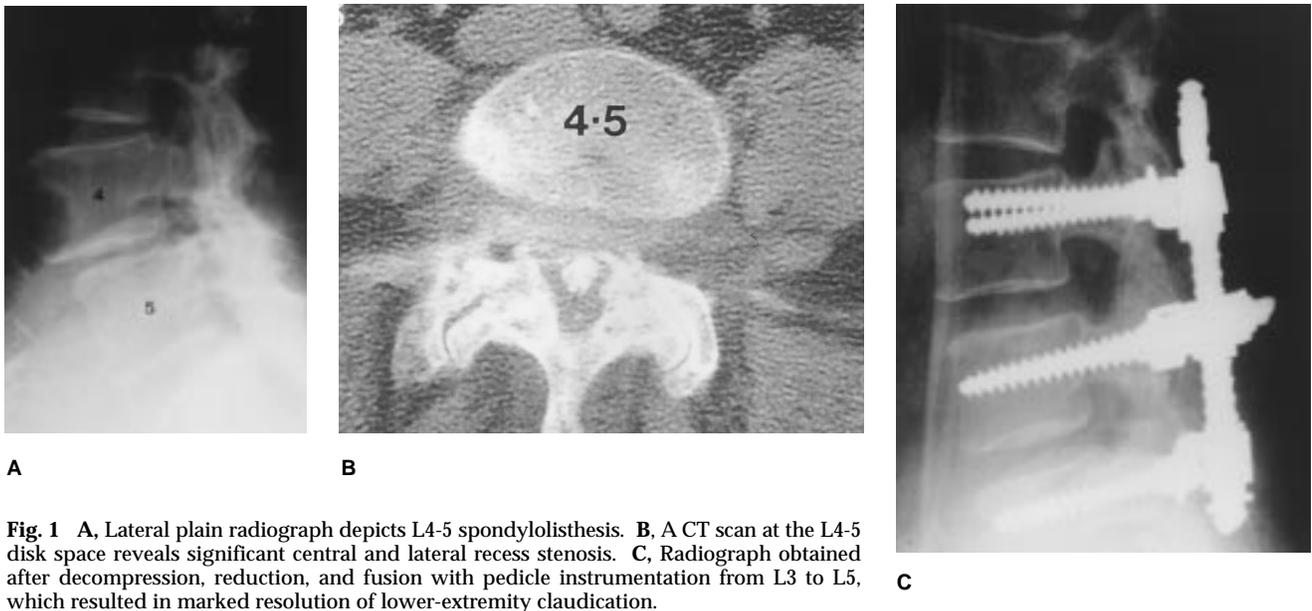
A, Lateral plain radiograph depicts L4-5 spondylolisthesis. B, A CT scan at the L4-5 disk space reveals significant central and lateral recess stenosis. C, Radiograph obtained after decompression, reduction, and fusion with pedicle instrumentation from L3 to L5, which resulted in marked resolution of lower-extremity claudication.
